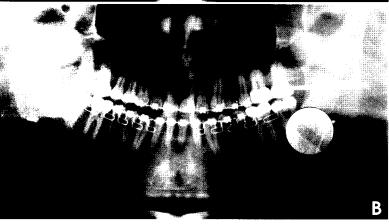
A. Example of panoramic radiographs after BSSRO. Bony gap is seen on both sides of mandible. B. Bright round area shows an analyzed site in this study.
